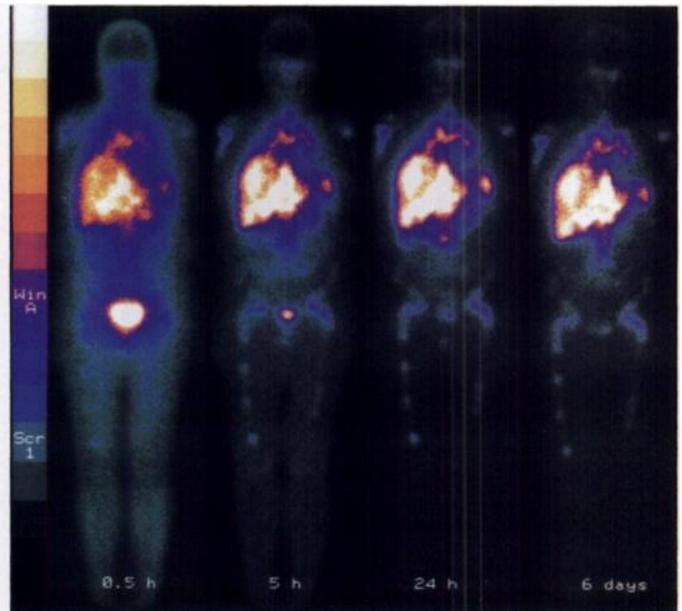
Anterior views of whole-body scintigraphy performed 0.5, 5, 24 h and 6 days after injection of 280 MBq $^{111}\text{In-DTPA-D-Phe}^1\text{-octreotide}$.
